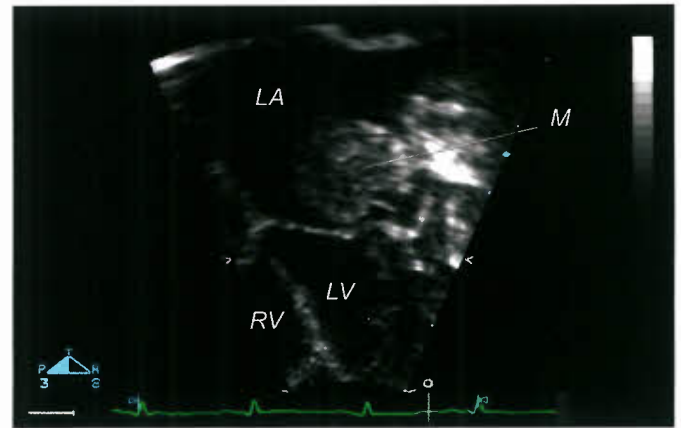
Two-dimensional echocardiogram in a 2-year-old child with a left atrial myxoma (M). LA, left atrium; LV, left ventricle; RV, right ventricle.
